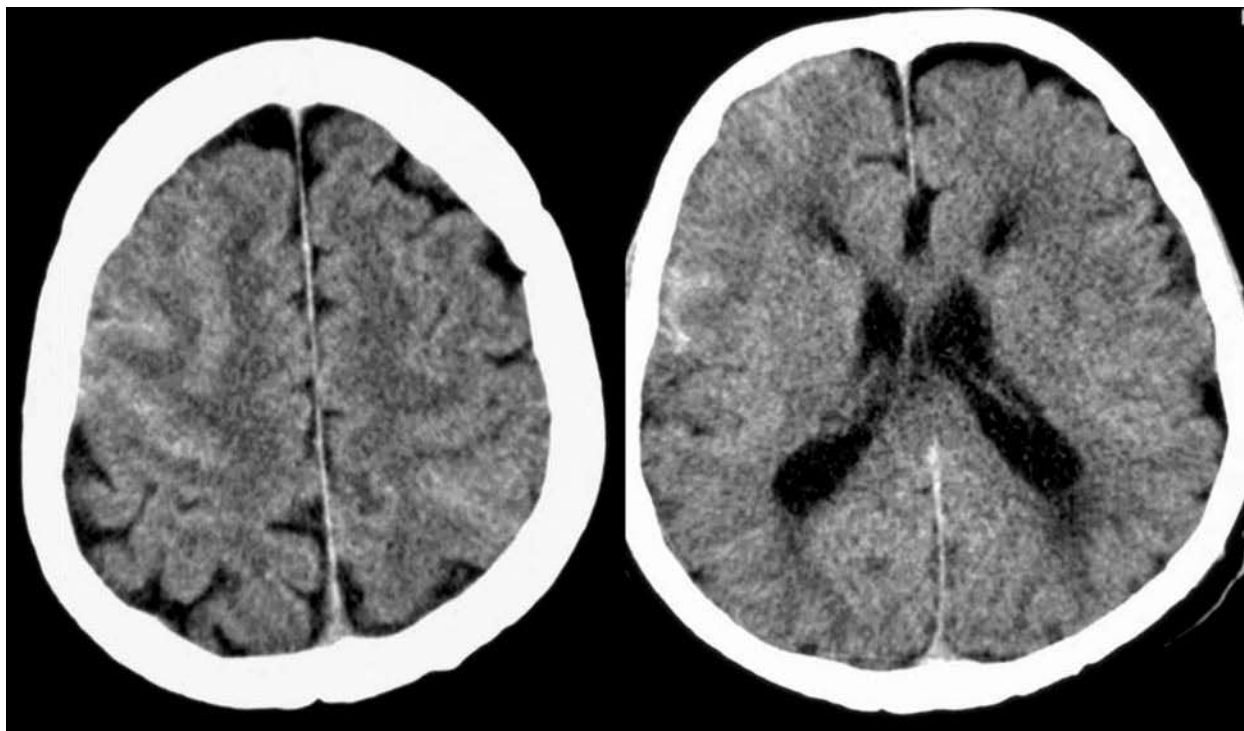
Computed tomography in axial plane shows bleeding into the subarachnoid space of the frontal and parietal lobes on both sides (subarachnoid hemorrhage).
